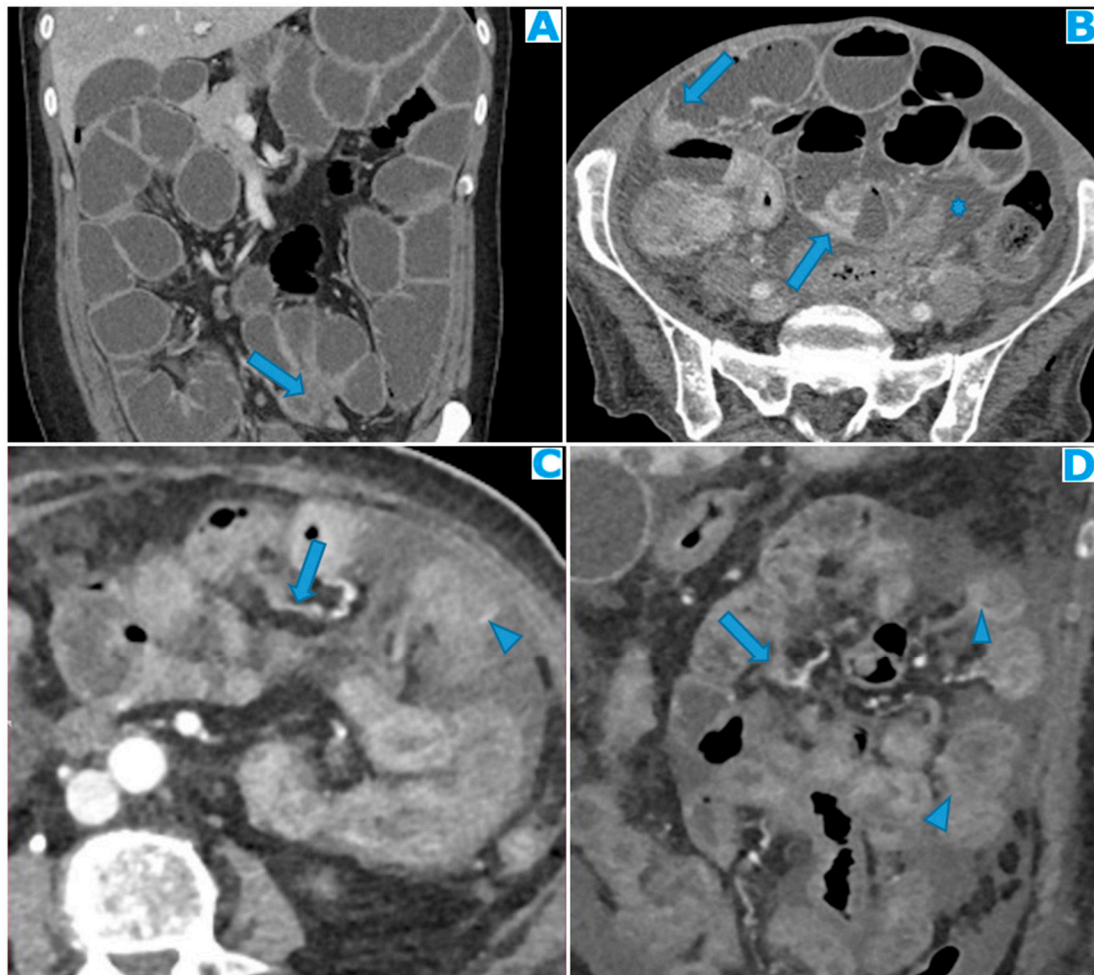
Coronal MPR (A). PC from mucinous colon adenocarcinoma: Solitary mesenteric deposit (arrow) as the cause of a SB obstruction, involving several loops. Axial CE-CT (B). PC from breast carcinoma: SB multifocal obstruction, due to several deposits within the SB serosa (arrows). Ascites (*). Axial CE-CT (C) and coronal MPR (D). PC from adenocarcinoma of the urachus: Severe mesenteric infiltration causing SB ischaemia as distal SMA and SMV branches are compressed and infiltrated by deposits (arrows). Observe the SB loops thickening and the heterogenous and patchy bowel wall enhancement (arrowheads) due to the ischaemia.
